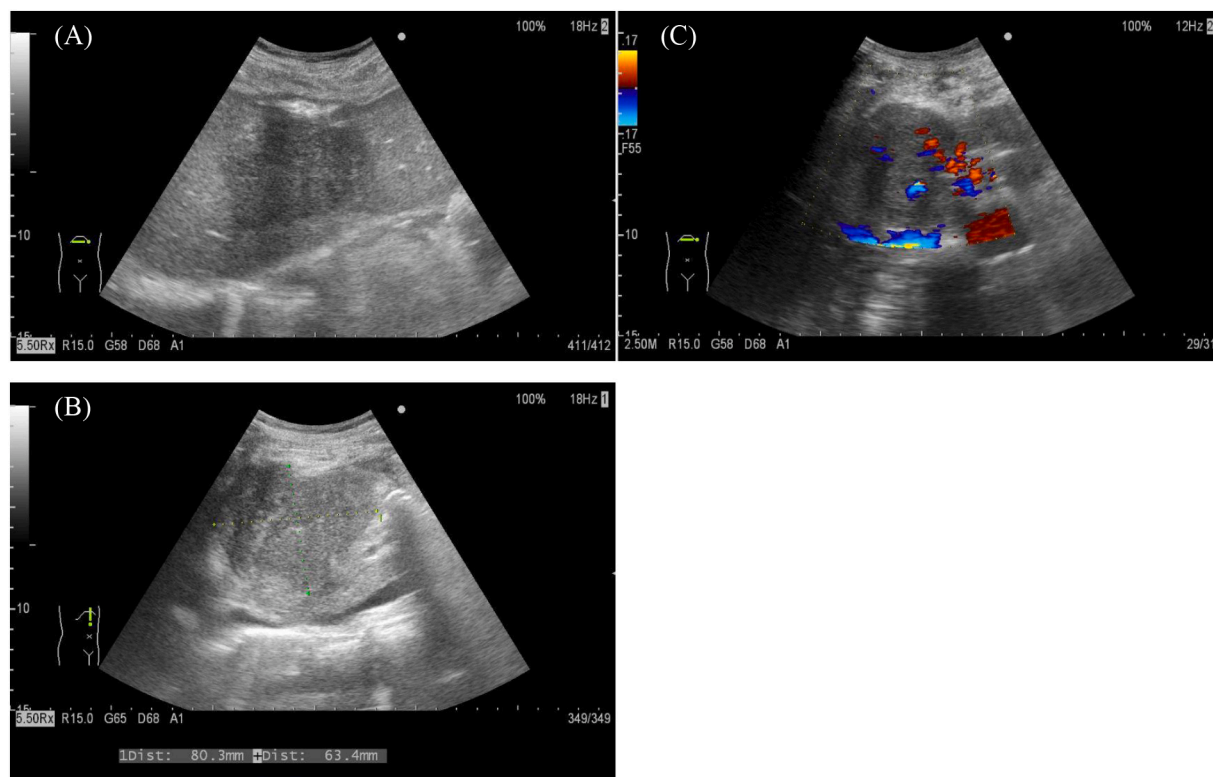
Abdominal US. A: horizontal section of liver tumor. B: sagittal left oblique section. C: doppler ultrasound showed heterogeneous hypoechoic mass.
